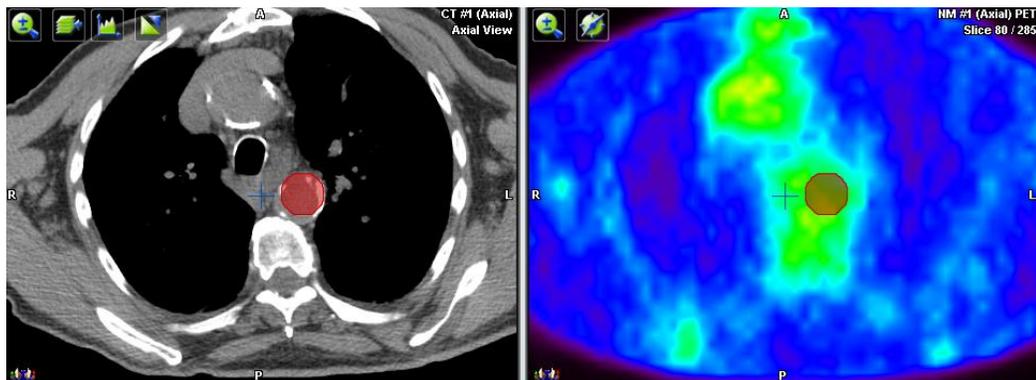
Fused images of pre-treatment CT and pre-treatment PET. Green circle indicates the treatment area.
